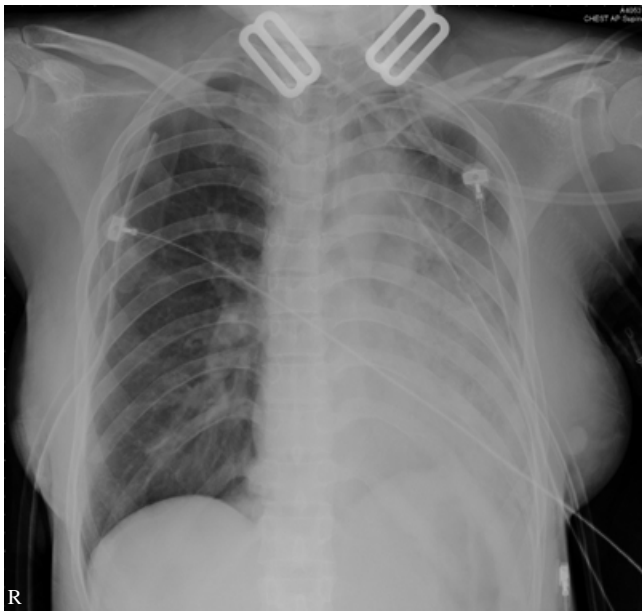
Chest X-ray disclosed hyperinflation of right lung and collapse of left lower lung. There was no fallen-lung sign or pneumothorax noted.
